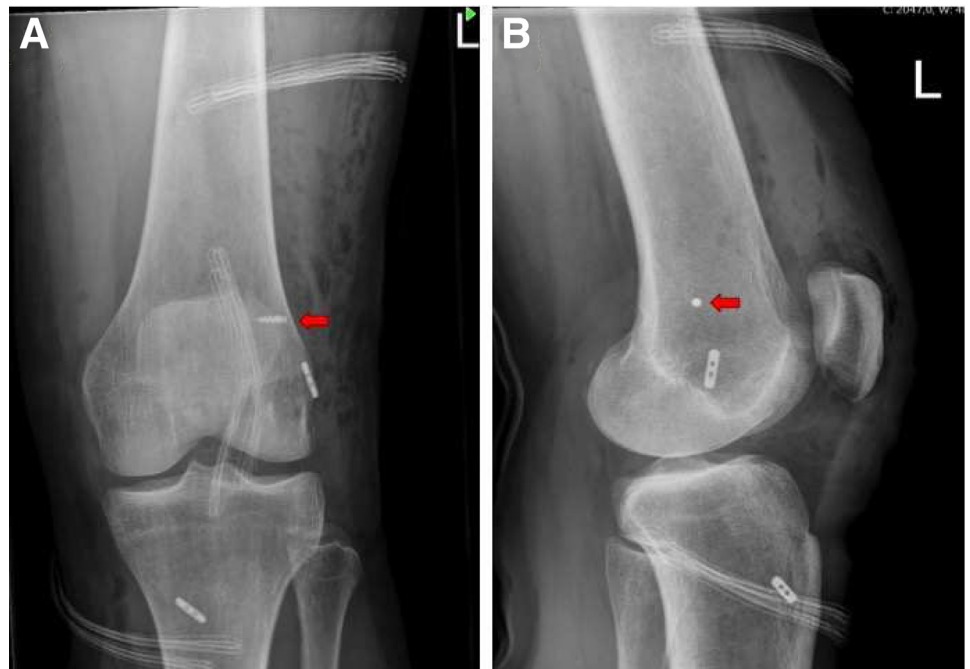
Radiographic imaging of the left knee after all-inside anterior cruciate ligament reconstruction combined with minimally invasive modified Lemaire tenodesis. (A) Anteroposterior image. (B) Lateral image. The red arrow marks the titanium suture anchor (FASTak; Arthrex).
